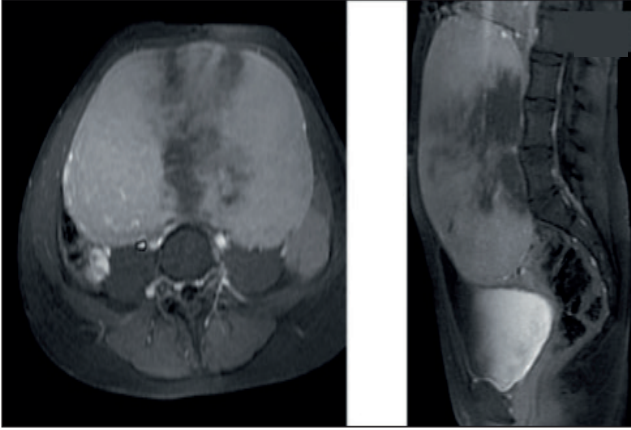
The MRI view of the mass.
